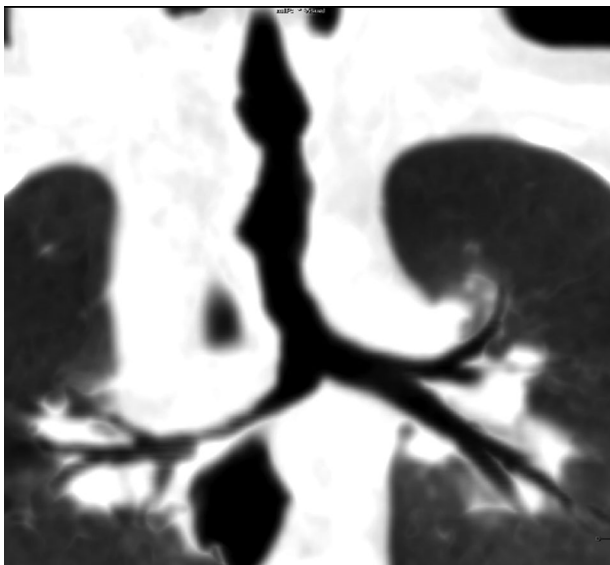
Follow-up CT-scan after eight consecutive biodegradable stents showing tracheal growth with an enhanced diameter.
